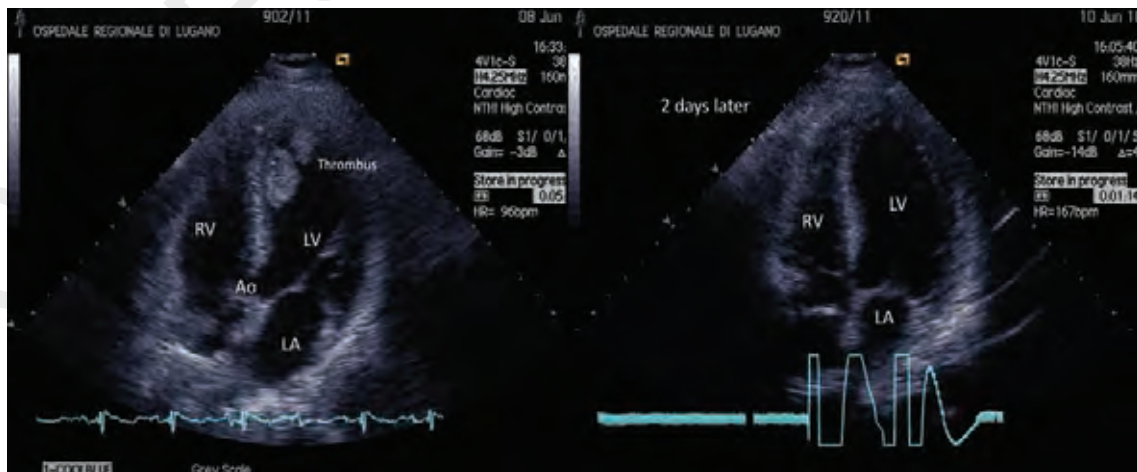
Acute phase and two-day follow-up transthoracic echocardiography. Right. LV= left ventricle with akinetic apex and thrombus. LA=left atrium; RV=right ventricle; AO=aorta. Left. After only two days complete resolution of the thrombus under anticoagulation therapy.
